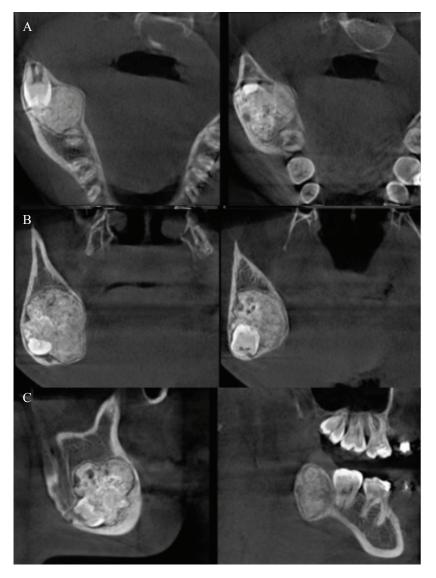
shows (A) axial, (B) coronal, and (C) sagittal CBCT images displaying a well-defined amorphous radiopaque mass with bucco-lingual expansion. The lesion displaces the inferior alveolar canal and the mandibular right third molar. Root resorption of mandibular right second molar is not observed.
